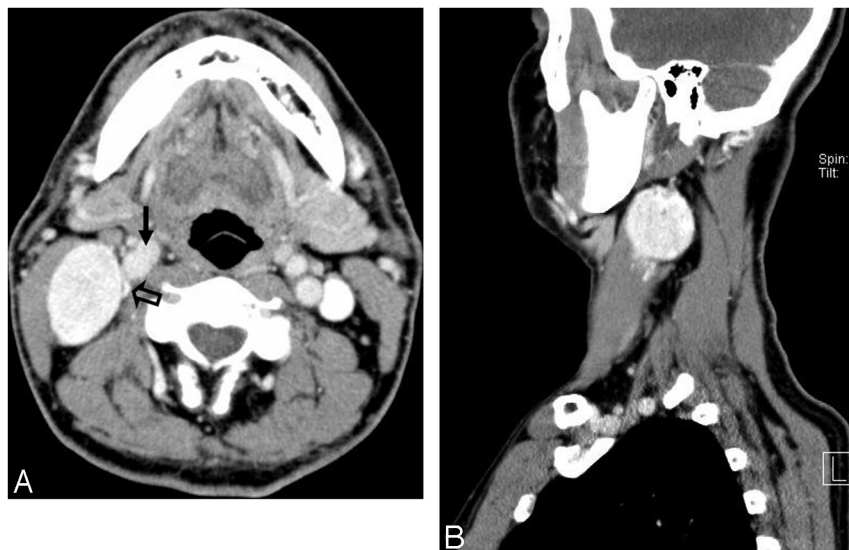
Axial contrast-enhanced CT (A) and sagittal contrast-enhanced reformatted (B) images reveal a well-defined ovoid mass with homogeneous intense enhancement. The degree of enhancement is as intense as that of vascular structures. The mass is located posterolateral to the internal and common carotid arteries (arrow) and the compressed internal jugular vein (open arrow). These structures are displaced anteromedially by the mass.
